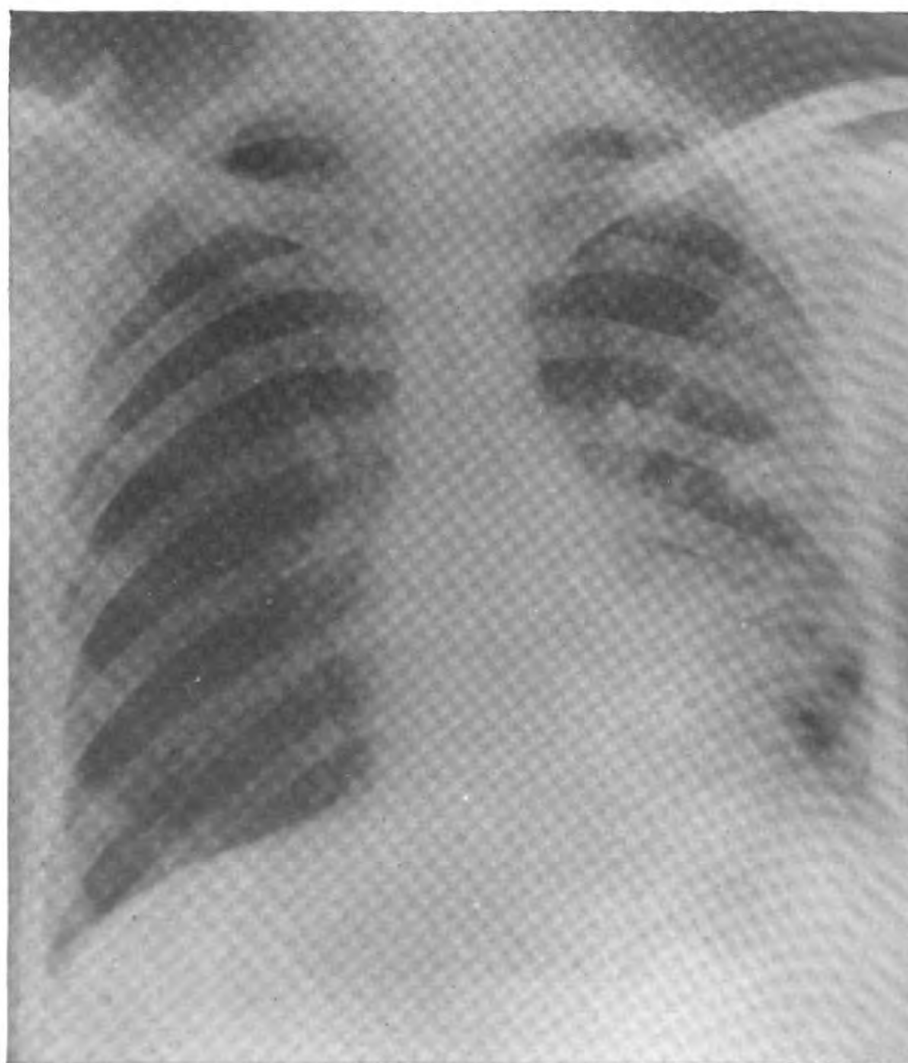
X-ray on 1 October 1945 showing beginning resolution of the process with a suggestion of small cavities in middle lobe.
